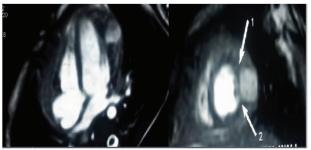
MRI Chest showing the pseudoaneurysm arising from the posterolateral LV free wall and the narrow neck of the sac
